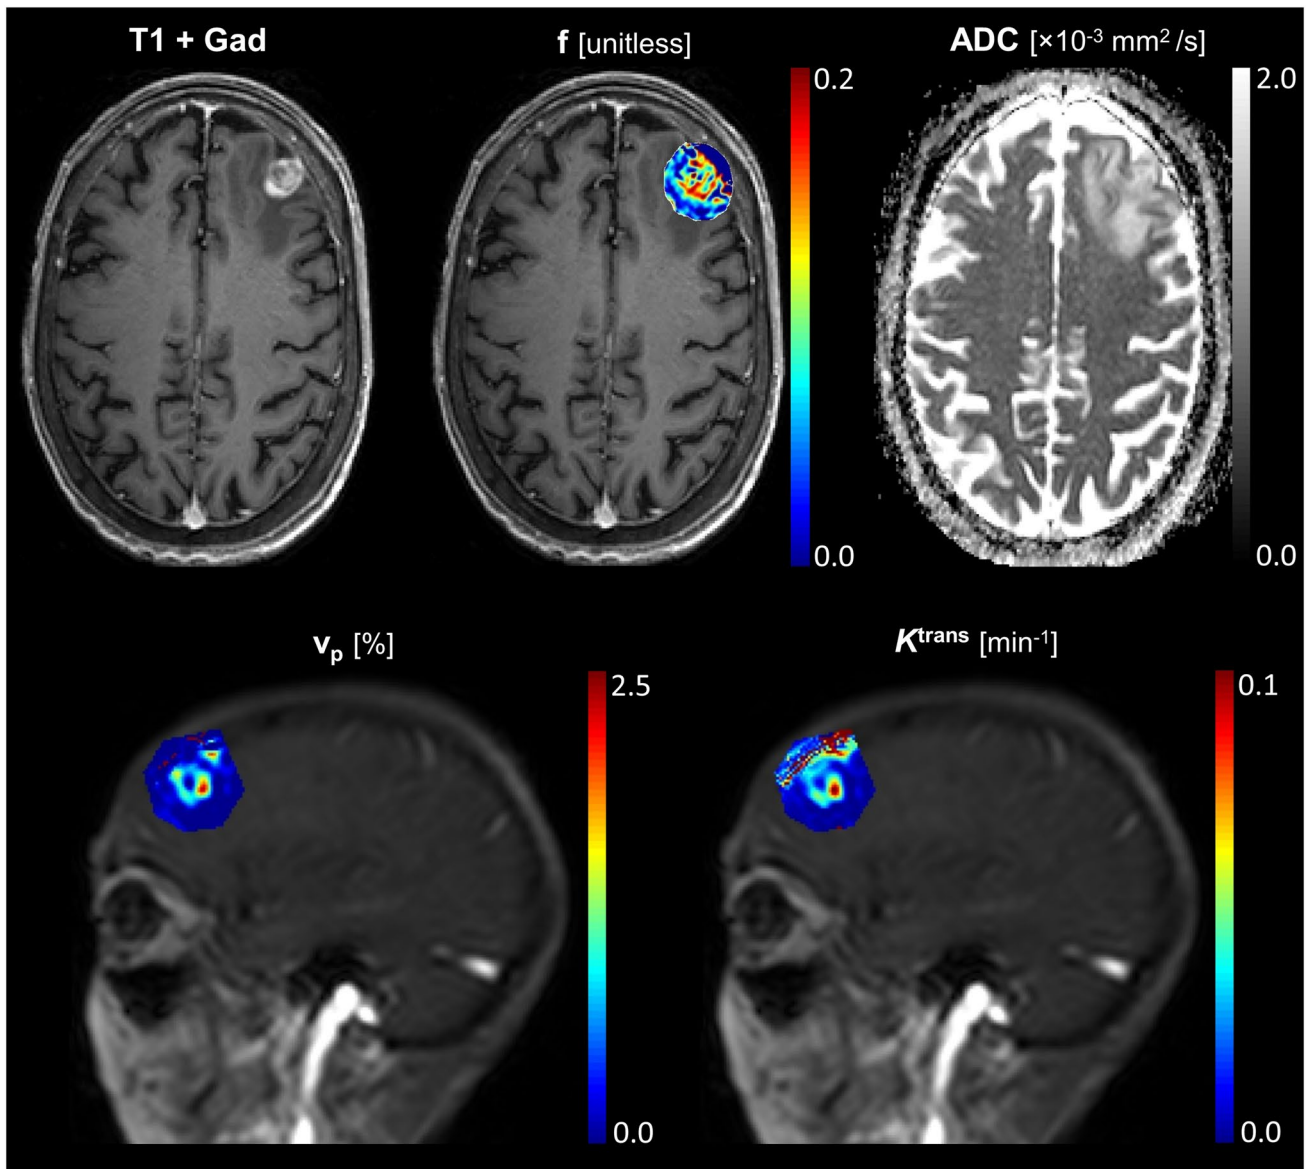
IVIM and DCE-MRI maps for a typical metastasis at baseline. Axial contrast enhanced T1-weighted image shows a centrally necrotic metastasis in left frontal lobe (*left top row*). Perfusion fraction (f) map overlaid on post-contrast image (*center top row*) shows elevated f in the periphery of the metastasis. The ADC map (*right*
